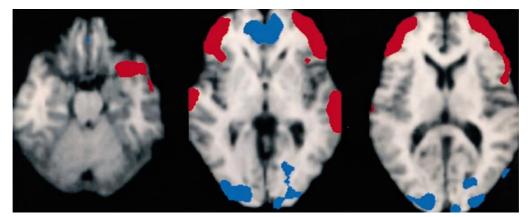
Statistical parametric map (SPM) of [¹¹C]flumazenil PET scan of a patient with bilateral subependymal heterotopia whose cortex appeared normal on high resolution MRI. The individual patient's PET scan has been compared with a bank of 24 normal subjects on a pixel-by-pixel basis, and the results mapped onto the patient's MRI scan. Areas of significantly increased binding to benzodiazepine receptors are shown in red and areas of significantly reduced binding in blue (figure supplied by Dr Mark Richardson).
